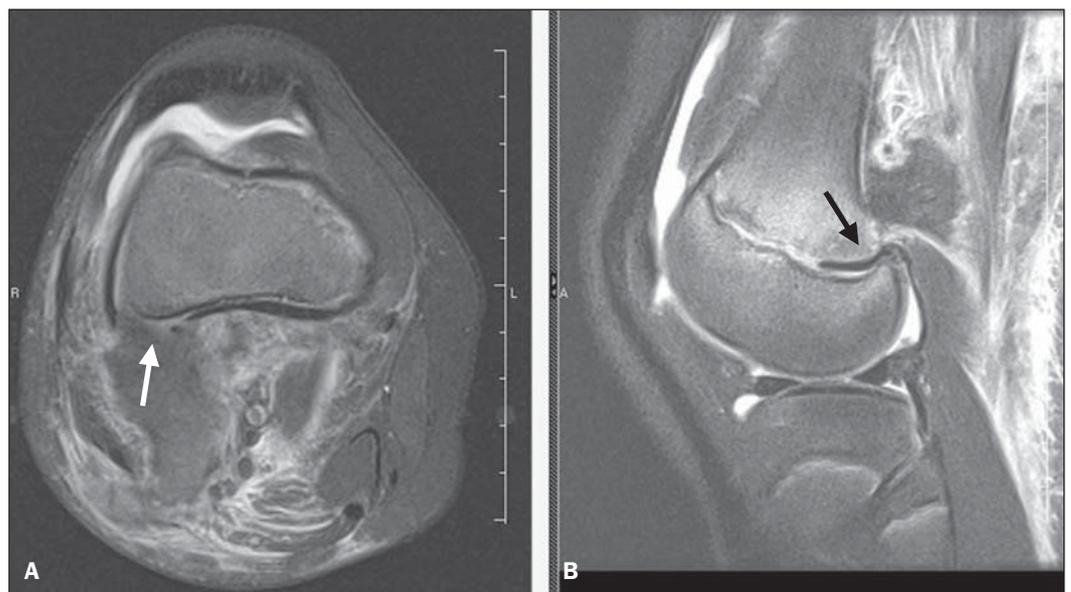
Magnetic resonance imaging, axial (A) and sagittal (B) T2-weighted images with fat saturation. Discontinuity in the posterolateral aspect of the cortical bone (A) associated with distension of the femoral biceps muscle and interposition of hypointense linear structure along the epiphyseal plate, compatible with periosteal fragment (B).
